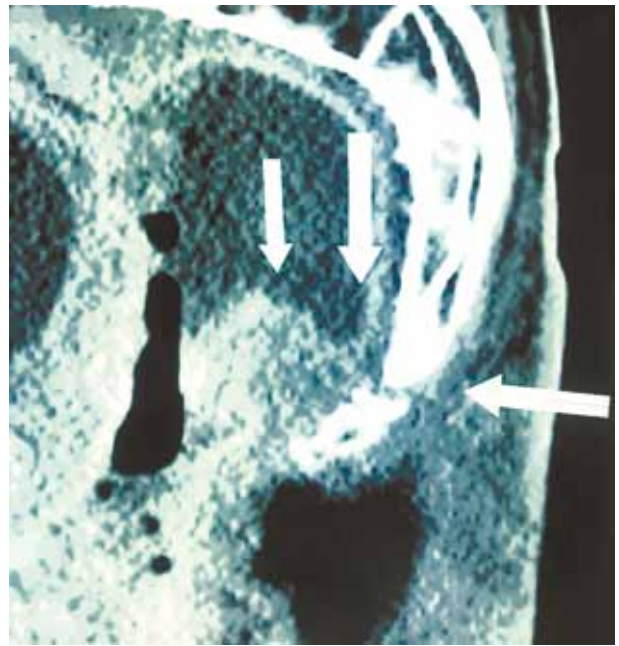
CT scan of presacral area. The arrows show a recurrent tumor (arrows from above) and the area of pathological fracture (right arrow)
